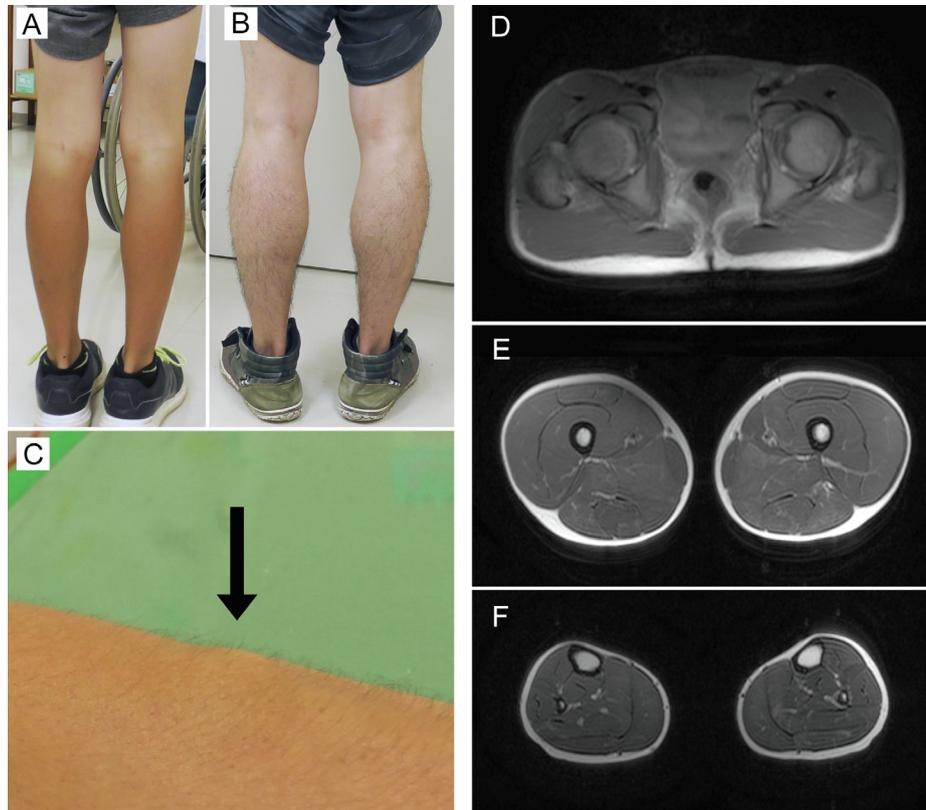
(A) The proband (III-3), who presented with a *CAV3* mutation and a *DMD* deletion appearance, showed mild calf hypertrophy. (B) The father (II-1), who had a *CAV3* mutation, also had mild calf hypertrophy. (C) Percussion-induced muscle mounding was found in the extensor carpi radialis longus of the father (II-1) (arrow). (D–F) Skeletal muscle magnetic resonance imaging of pelvis (D), thigh (E) and calf (F) showed neither the atrophy nor the lipomatous degeneration.
